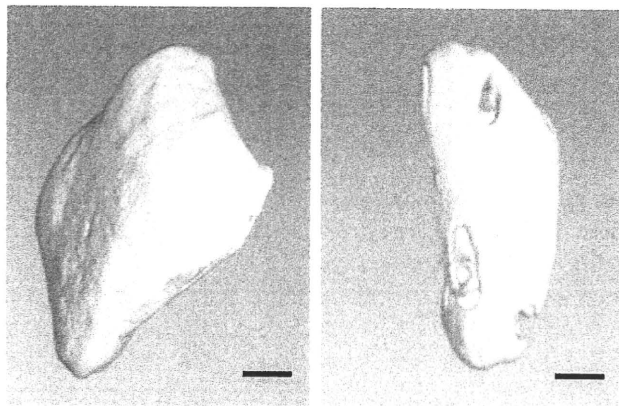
(Left) Representative three-dimensional computed tomographic image of high-luminescence bone grafts (scale bar = 100 μm). (Right) Representative three-dimensional computed tomographic image of low-luminescence bone grafts (scale bar = 100 μm).
